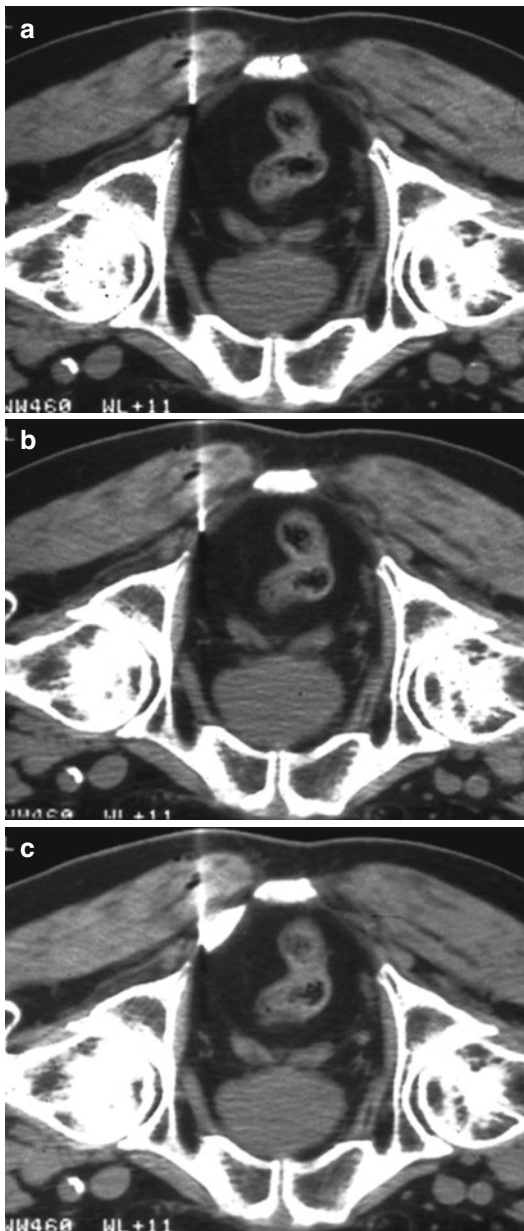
Pudendal nerve infiltration first site: sequential CT monitoring the needle tip progressing on the right to the ischial spine between the sacrospinous and sacrotuberous ligaments (a, b). Here, the added contrast media (not mandatory) diffuse between the sacrospinous and sacrotuberous ligaments (c; first site)
